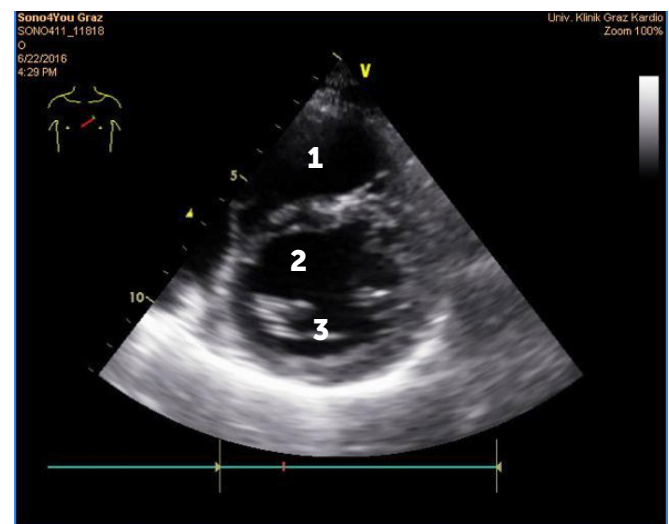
Parasternal short axis.
